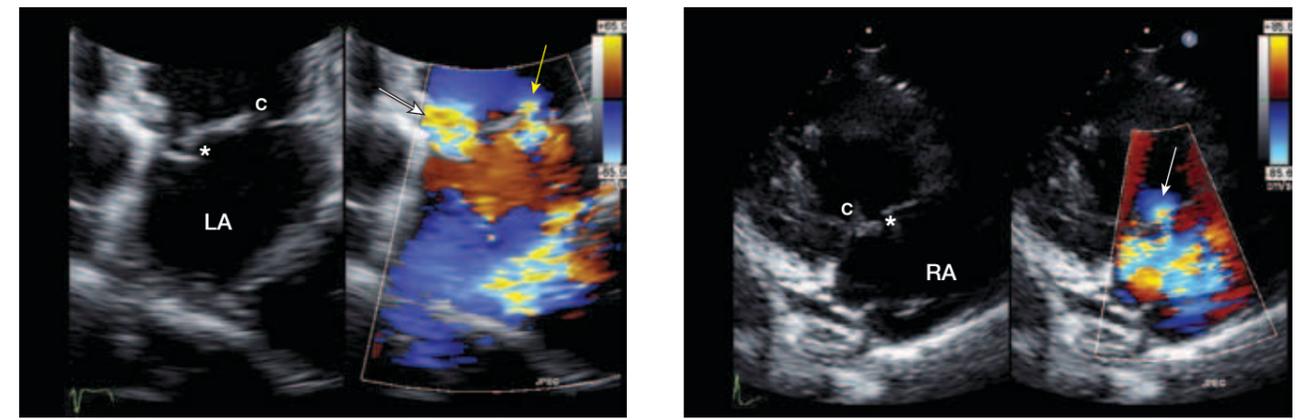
Two examples of leaflet perforation from two different patients are shown. The image on the left was recorded from a zoomed apical 4-chamber view. On the 2D image, a tissue defect is noted in the anterior mitral leaflet (*); on the corresponding colour Doppler image regurgitant flow through this defect is observed (white arrow). Observe that valvular regurgitation is also present at the site of leaflet coaptation (c) (yellow arrow). The image on the right was recorded from a parasternal long axis view of right ventricular inflow. On the 2D image, a tissue defect is noted in the anterior tricuspid leaflet (*) adjacent to the site of leaflet coaptation (c). On the corresponding colour Doppler image regurgitant flow through this defect is observed (white arrow). These appearances are consistent with leaflet perforation. LA = left atrium; RA = right atrium.
